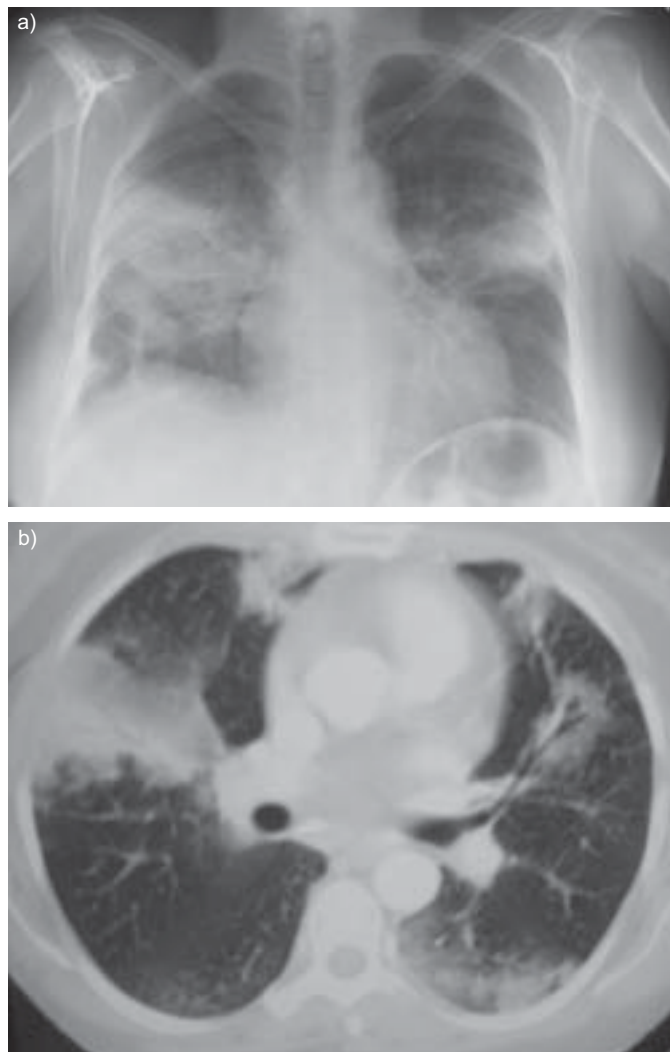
Typical cryptogenic organising pneumonia showing patchy bilateral alveolar opacities on a) chest radiograph and b) high-resolution computed tomography scan.
